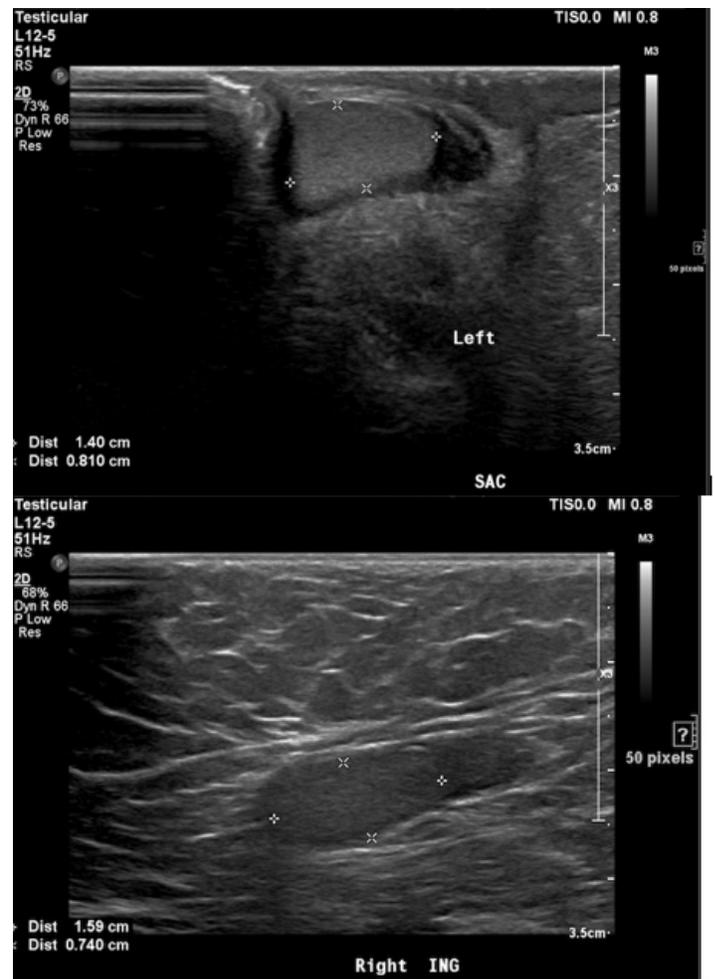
An Ultrasound of both testes.
